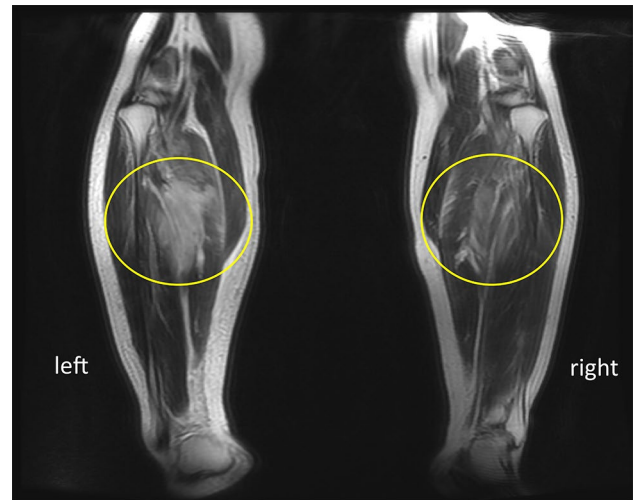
MRI image of the lower extremities after surgery in case 2. Contusions of the gastrocnemius muscles of both legs (*left > right*)
